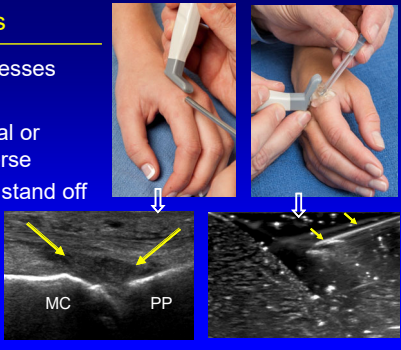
shows two clinical photographs of an ultrasound probe being applied to the MCP joints. Below are two B-mode ultrasound images. The left image shows a parasagittal or transverse view of the MCP joint with two yellow arrows pointing to the joint space, labeled 'MC' and 'PP'. The right image shows another view of the MCP joint with two yellow arrows pointing to the joint space.
